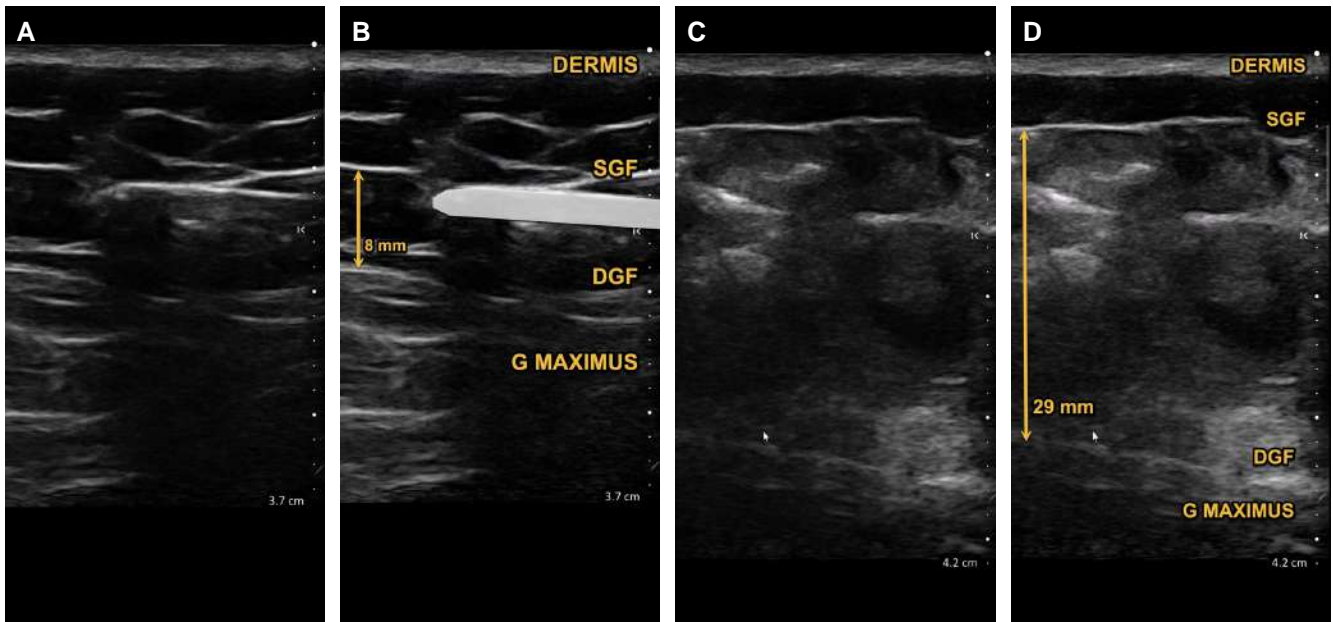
Static injection, migration, and equalization: Case 2. (A) Preinjection original sonogram: the cannula is noted within the deep subcutaneous space directly beneath the SGF. The deep subcutaneous space has a preinjection height of 8 mm. Note the sonographic shadow artifact obscuring the view of the deeper structures beneath the cannula. (B) Preinjection annotated sonogram. (C) Postinjection original sonogram: injected fat graft has now filled the deep subcutaneous space and displaced the DGF downward and the SGF upwards. Both fasciae remain intact, and the height of the deep subcutaneous space has now increased by a factor of 3.6. (D) Postinjection annotated sonogram. DGF, deep gluteal fascia; SGF, superficial gluteal fascia
